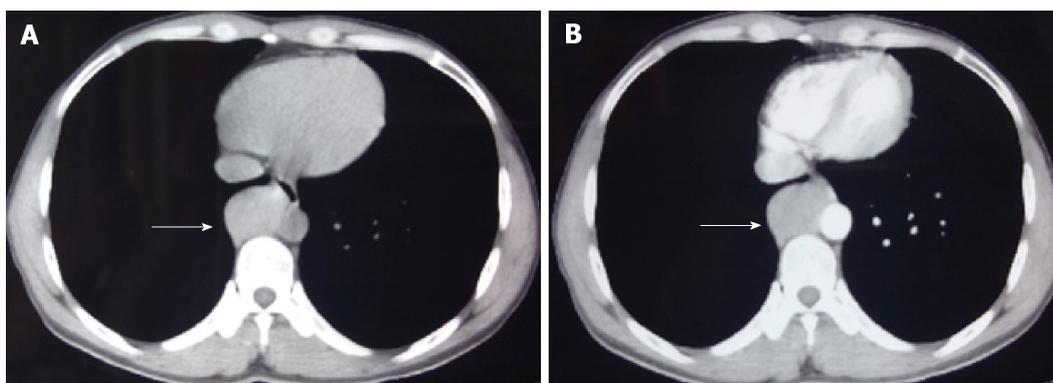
Chest computed tomography. The oval tumor (shown by the arrows) was located on the lateral wall of the abdominal aortic artery, with uniform density and a size of about 4.5 cm × 3.0 cm. The boundary with surrounding tissues is clear. The computed tomography (CT) value of the flat scan is about 57 HU (A), and the enhanced CT value is about 113 HU (B).
